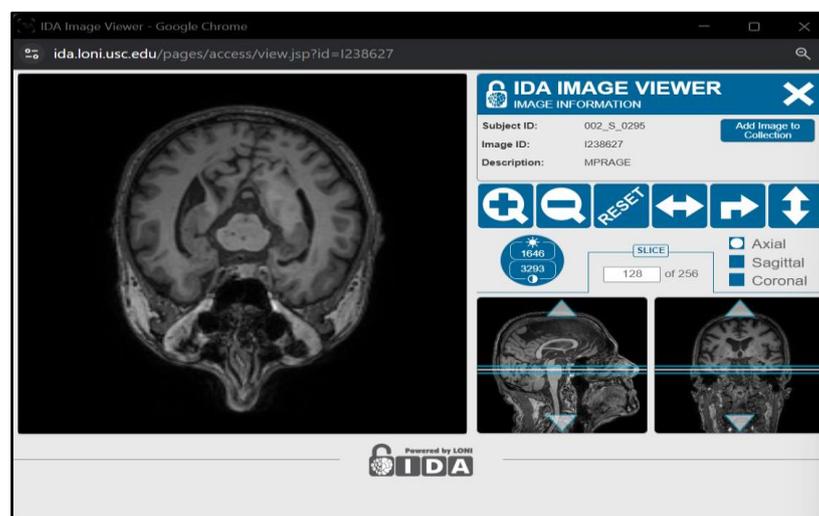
a 3D brain MRI scan acquired from the Alzheimer's Disease Neuroimaging Initiative (ADNI) using T1-weighted imaging.
